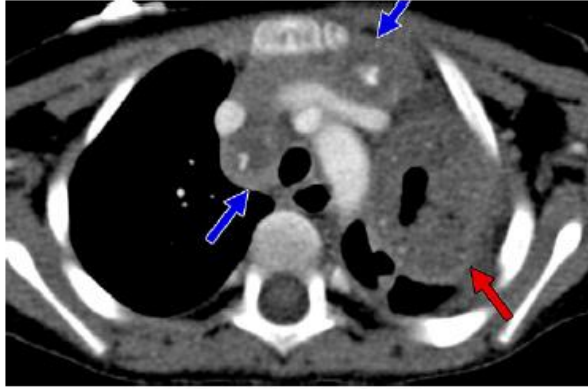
Chronic pneumonia with lymphadenopathy caused by disseminated *Mycobacterium tuberculosis* in a 2-year-old boy. Axial contrast-enhanced CT shows mediastinal (blue arrows) and hilar (not shown) lymphadenopathy with central low attenuation, peripheral rim enhancement, and calcification. A left upper lobe mass with cavitation and punctuate calcification is consistent with a cavitating tuberculoma (red arrow).
